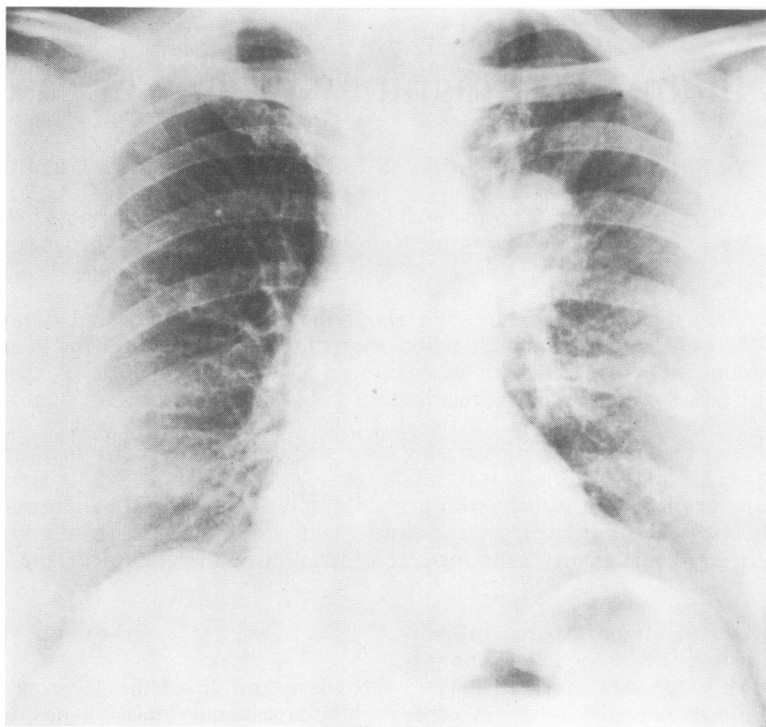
Chest radiograph of a 66-year-old man showing a bronchial carcinoma in the apicoposterior segment of the left upper lobe.*
